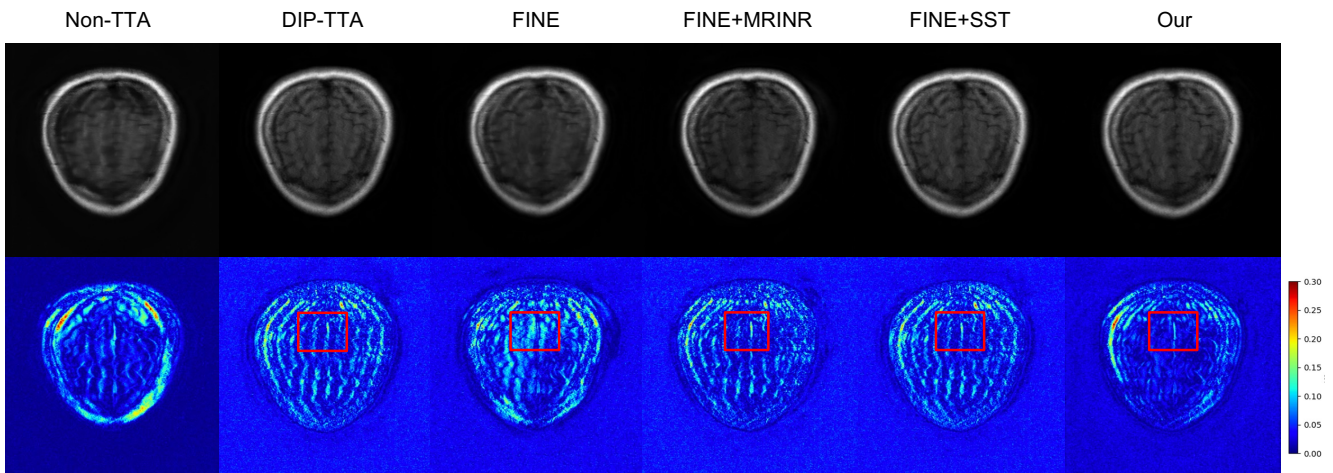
Comparison of different frameworks in Varnet under modality shift (AXT2 to AXT1PRE) using the FINE method. The first row shows reconstructed MRI images, while the second row presents residual maps between reconstructions and full-sampled MRI.
